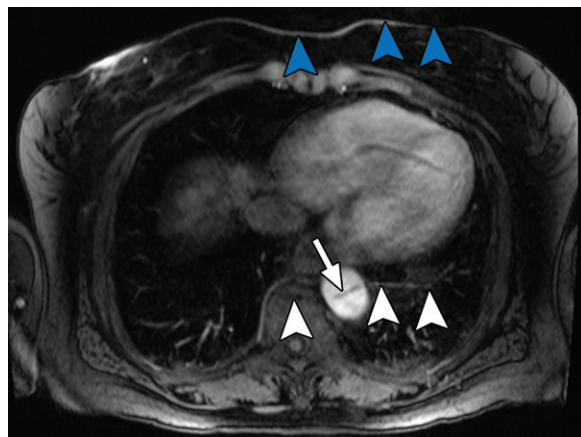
Parallel imaging wrap artifact mimicking aortic dissection in a 63-year-old woman who underwent liver MRI. Axial T1-weighted arterial phase MR image shows an apparent “dissection flap” in the descending thoracic aorta (arrow). However, the line extends outside of the aorta, overlying the spine and left lung (white arrowheads), and recapitulates the anterior abdominal wall (blue arrowheads), consistent with an “unwrapping” artifact from parallel imaging reconstruction on an older MRI scanner.
